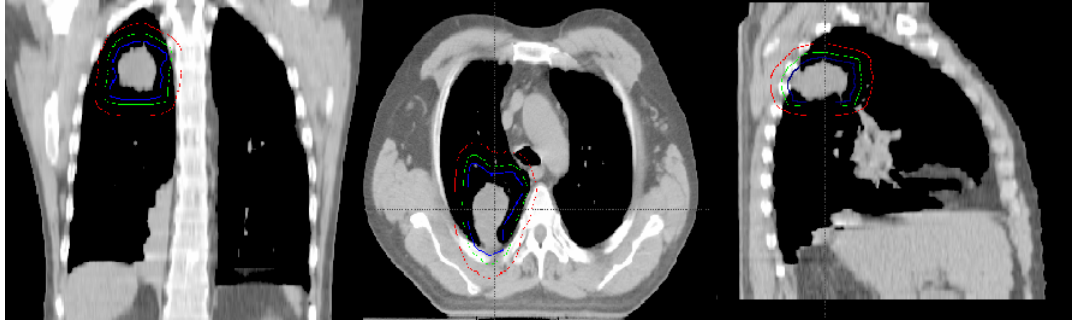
Coronal, axial and sagittal CT images of a patient with delineated target volumes GTV (blue), CTV(green) and PTV(red)
